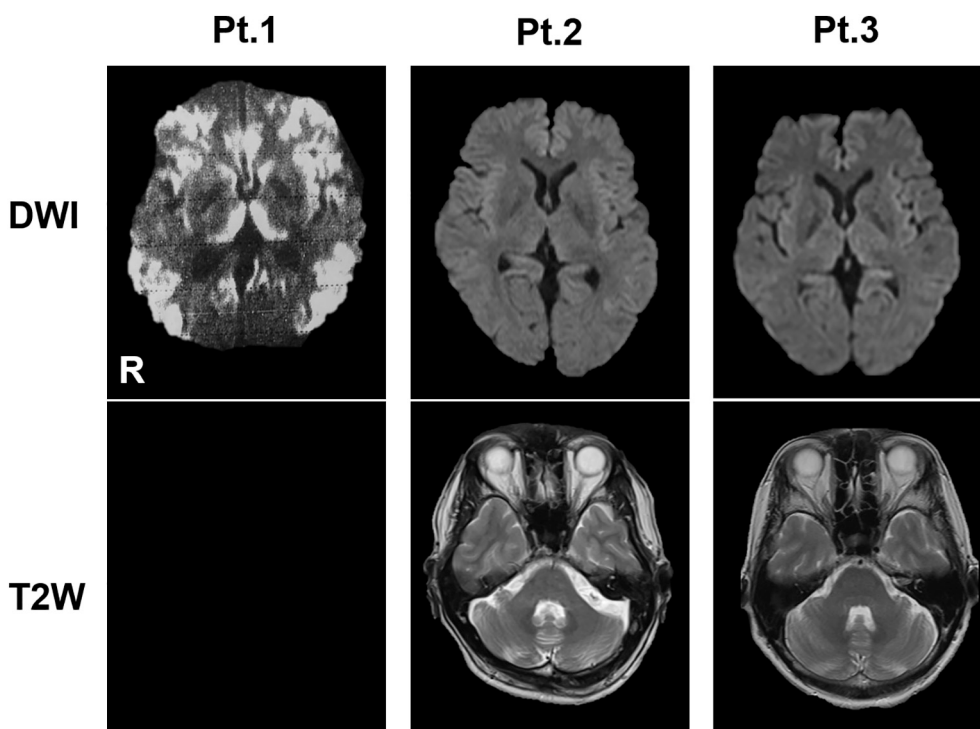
Brain MRI on admission. DWI image in patient 1. DWI and T2W image in patients 2, 3. Only Pt 1 MRI revealed high signals in the occipital and frontal cortices, and in the thalamus. Pt 2 and Pt 3 MRI had no abnormal signals, but the cerebellum in Pt 2 had mild atrophy. (MRI, Magnetic resonance imaging. DWI, diffusion weighted image, T2W, T2 weighted image).
